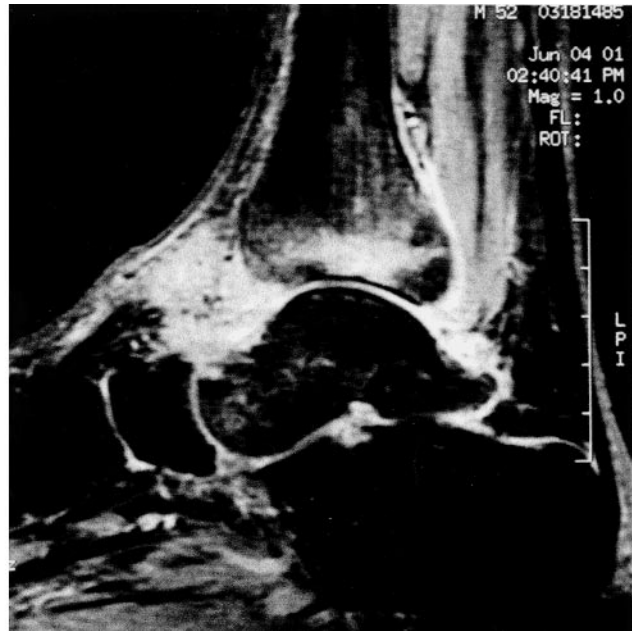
Sagittal MR images at the time of initial examination. Signal intensity in the neck and head of the talus was decreased in T1 weighted images (a), slightly increased in T2 weighted images (b), and increased in both STIR (c) and fat suppressed gadolinium enhanced T1 weighted images (d).
